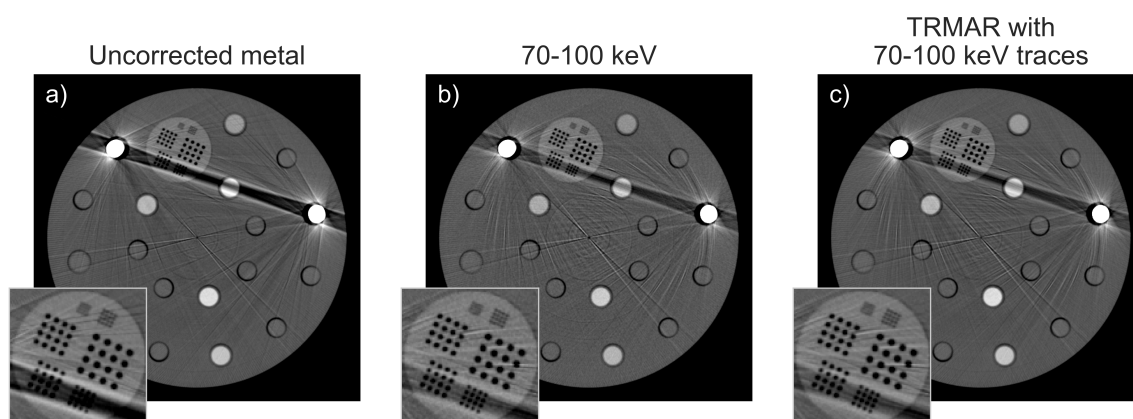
CT reconstructions a) with uncorrected metal in the 30–120 keV bin. b) with uncorrected metal in the 70–100 keV bin, and c) using trace replacement with 70–100 keV metal traces in the 30–120 keV image. W/L = [1300/150 HU].
